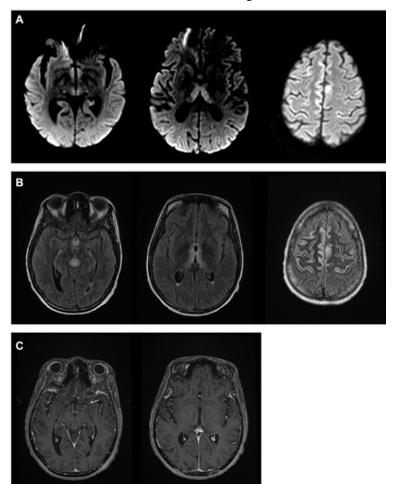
Initial MRI scan showing anomalies in DWI of mamillary bodies, periaqueductal, thalami and frontal cortex: high DWI (A), high flair intensity (B) and contrast-enhancement T1 weighted (C).
